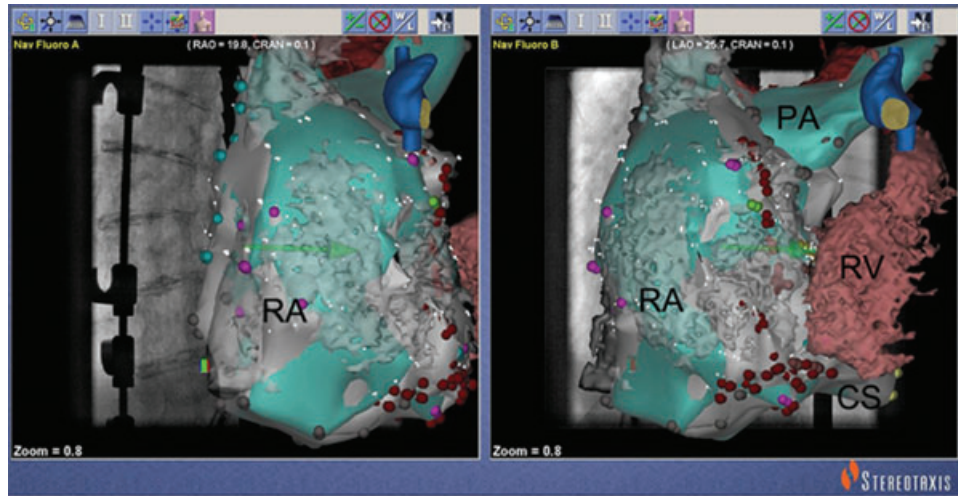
Navigation fluoroscopy window of Stereotaxis in a right anterior oblique (RAO; left window) and left anterior oblique (LAO; right window) view. An example of a patient with tricuspid atresia after the Fontan operation is shown. Overlapping with a real-time fluoroscopy image, atrial anatomy (green) was created by the CartoRMT system combined with RMN and was merged with a segmented 3D-CT image (gray) of the patient. The two 3D anatomies fit each other in size and in shape. CS = coronary sinus; PA = pulmonary artery; RA = right atrium; RV = hypoplastic right ventricle.
